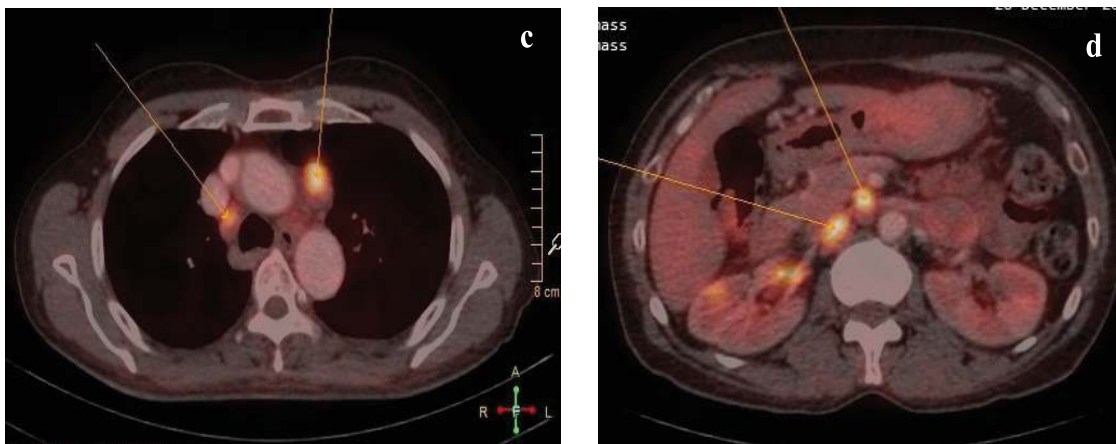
From left to right -transaxial ¹⁸F-FDG PET-CT fused images of chest ,neck, mediastinum and abdomen demonstrating a) large, hypermetabolic, irregular, soft tissue density mass involving upper lobe of left lung consistent with metabolically active primary malignancy; b) lower part of neck showing hypermetabolic enlarged right supraclavicular lymphnodes (arrows); c) bilateral hypermetabolic enlarged mediastinal lymphnodes and d) abdominal lymphnodes (arrows).
